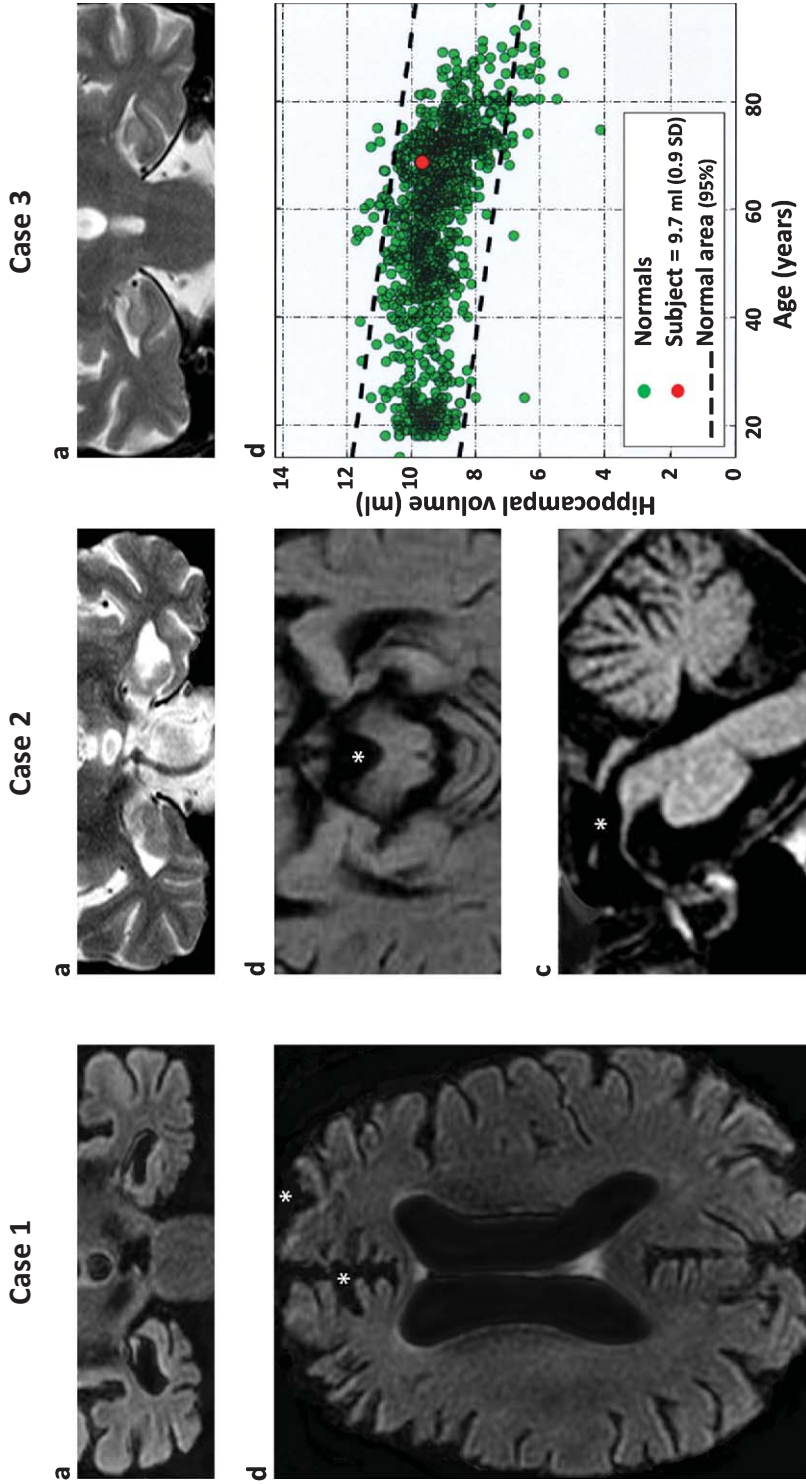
Assessment of brain atrophy by structural MRI in the three reported cases. In Case 1 and Case 2, MRI shows HA (a, first column and second column), whereas there is no HA in Case 3 (a, third column). In Case 1, MRI also reveals prefrontal atrophy (b, first column; indicated by asterisks), and in Case 2, there is midbrain atrophy (b, second column; indicated by an asterisk) as well as the midbrain “hummingbird sign” (c, second column; indicated by an asterisk). In Case 3, quantified region-of-interest based volumetry shows a total hippocampal volume of 9.7 ml (red spot) which was similar to hippocampal volumes in healthy controls (green spots) (b, third column).
